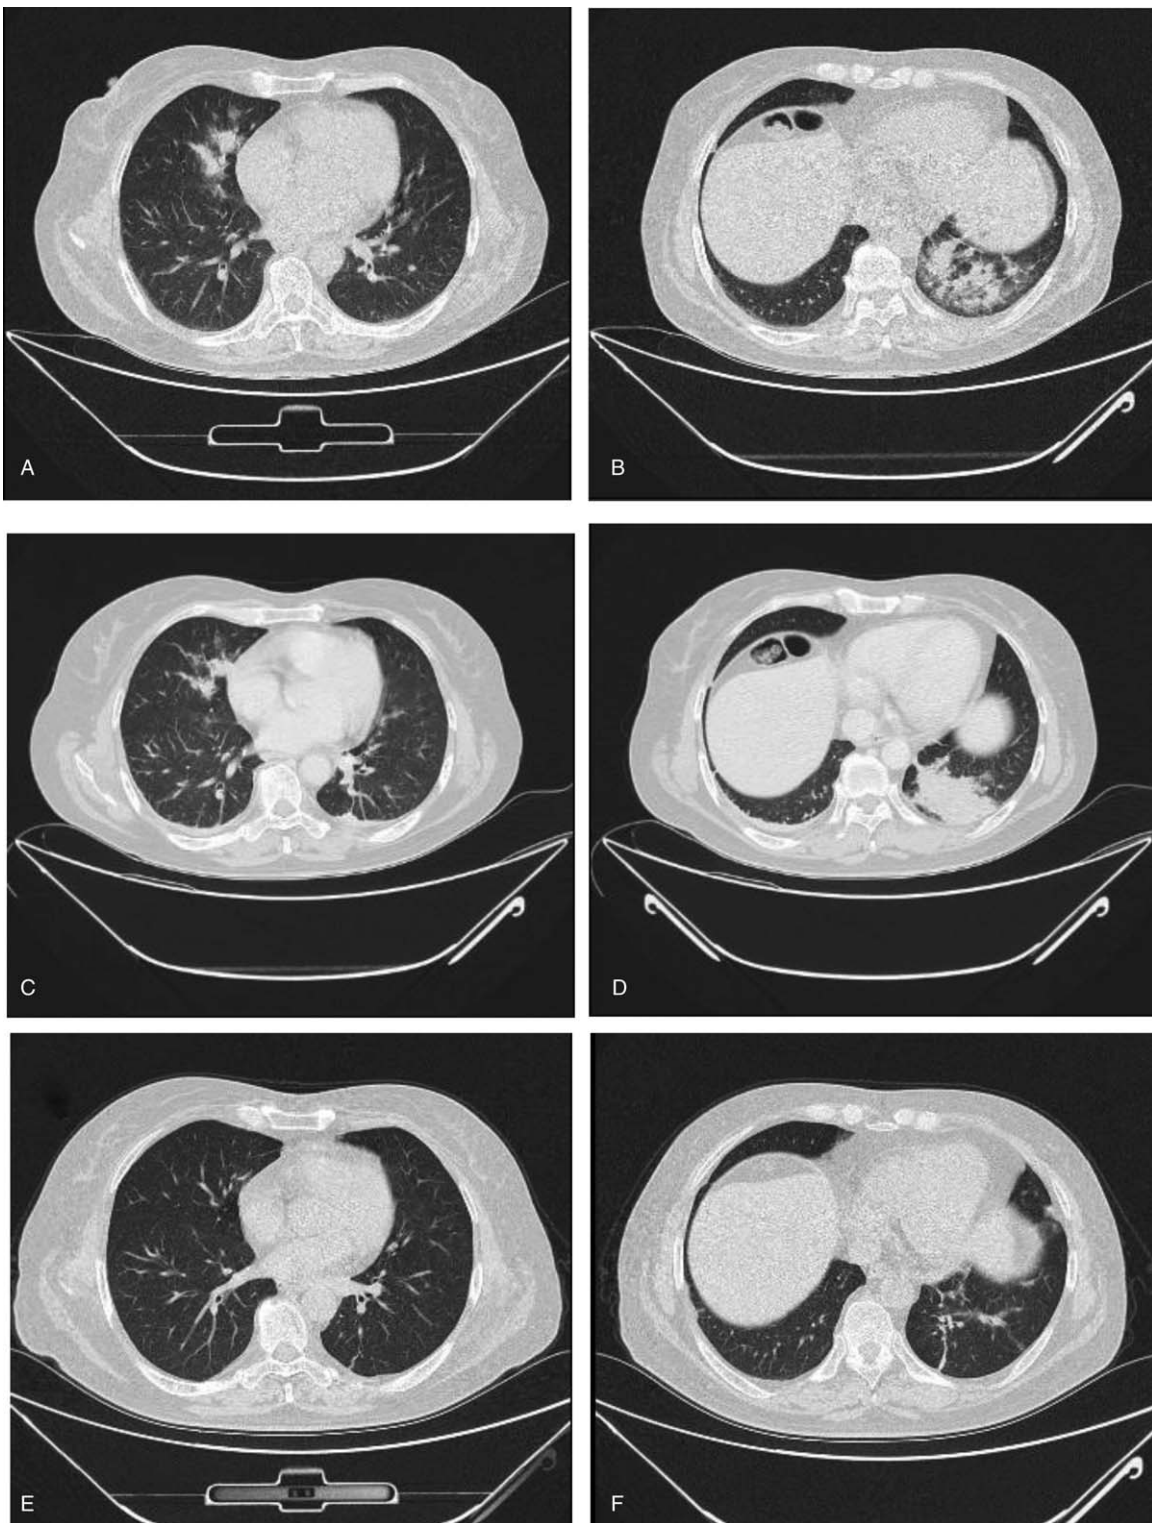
Chest computed tomography (CT) images. CT images at admission showing multiple bilateral patchy infiltrates (A, B). CT images at day 25 showing a large consolidation in the left lower lobe (C, D). Posttreatment (prednisolone) CT images showing alleviation of lesions (E, F).
